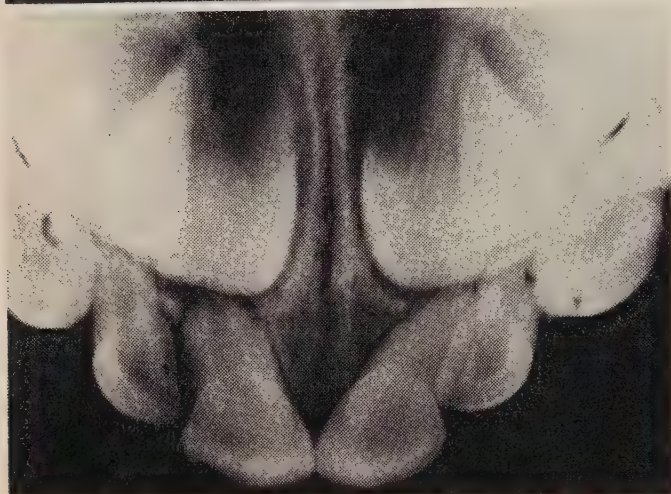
Left: radiograph shows advanced root resorption in an upper right deciduous central incisor. The tooth sustained a blow shortly after eruption but retained its natural colour and was shed normally. The permanent successor appears normal in this radiograph. Right: an area of hypocalcification, visible as a white patch, is present in the upper right permanent incisor. Such hypocalcification may not be evident in a pre-eruption radiograph.
